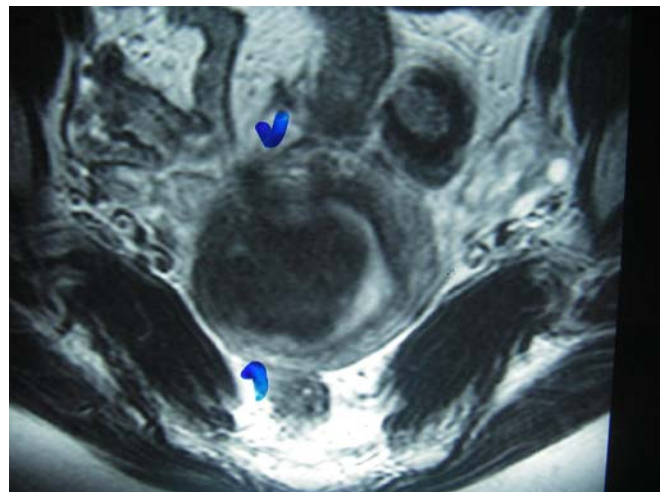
MRI of 40 mm submucous fibroid with intramural component
